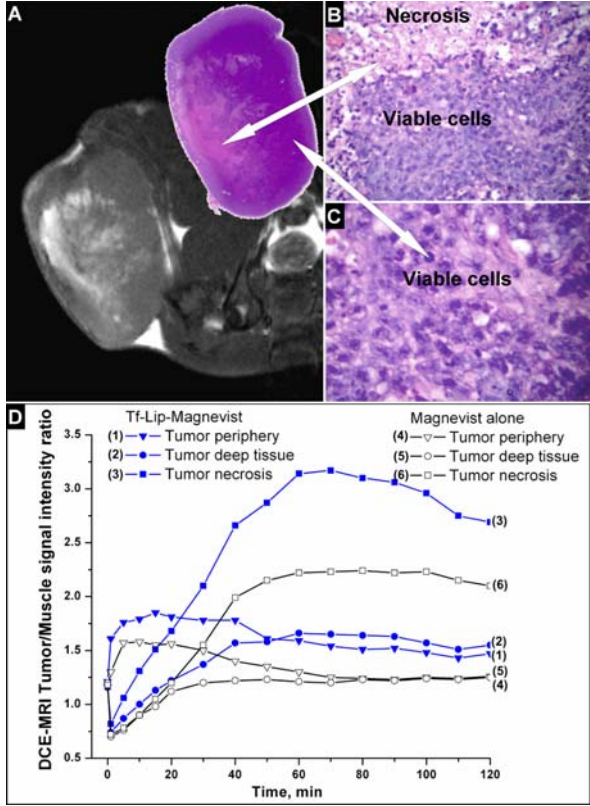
The probe-mediated MRI Image enhancement pattern (A) is well correlated with the pathological findings (B, C). Figure 2.A is a representative MR image showing heterogeneous enhancement pattern. Figure 2.B shows a region with high concentration of viable cells and necrosis (magnification $\times 250$). Figure 2.C shows the viable cells with high mitotic activity (magnification $\times 400$). In Figure 2.D, typical DCE-MRI curves show the MRI image intensities increase initially and later decrease at various rates for different regions in the tumor using either Tf-Lip-Mag liposomal nanocomplex or Magnevist. These distinct differences are due to the specific targeting and prolong retention of the Tf-Lip-Mag liposomal nanocomplex in the tumor.
